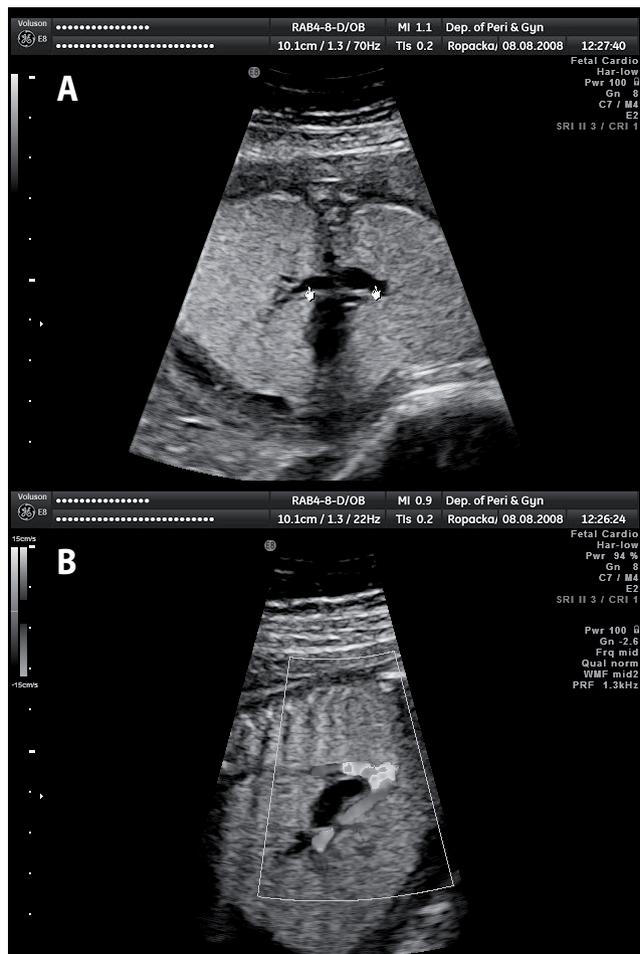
(A) ultrasound image of fetal thorax in transverse section in 23 weeks' gestation shows hyperechogenic, enlarged lungs with dilated distal airways (arrows) and mediastinal compression. (B) doppler ultrasound image of fetal thorax in sagittal section in 23 weeks' gestation shows aortic arch surrounding dilated distal airways (arrows).
